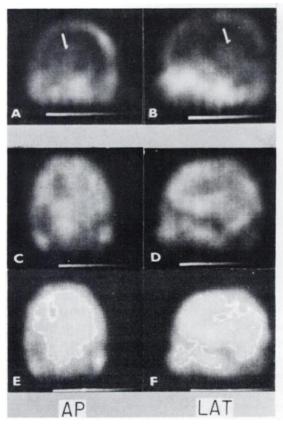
Positron scintigrams obtained in 45-year-old man with metastatic pulmonary adenocarcinoma. (A,B) Ga-ATP; (C,D) 1*NH₂.
